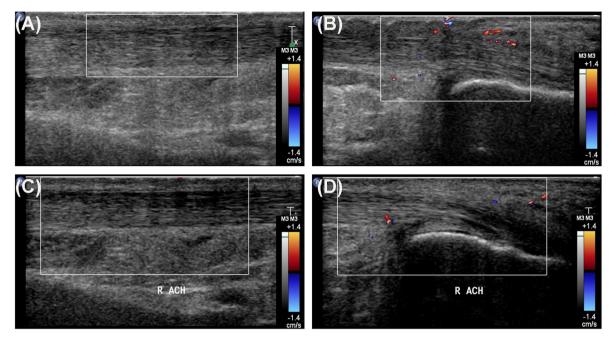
Ultrasonography images revealed neovascularization in the midportion part (A, C) and the insertional site (B, D) of Achilles tendon before treatment (A, B) and after treatment (C, D). After ESWT therapy, no obvious increase of neovascularization was observed in the Achilles tendon. ESWT, extracorporeal shock wave therapy.
